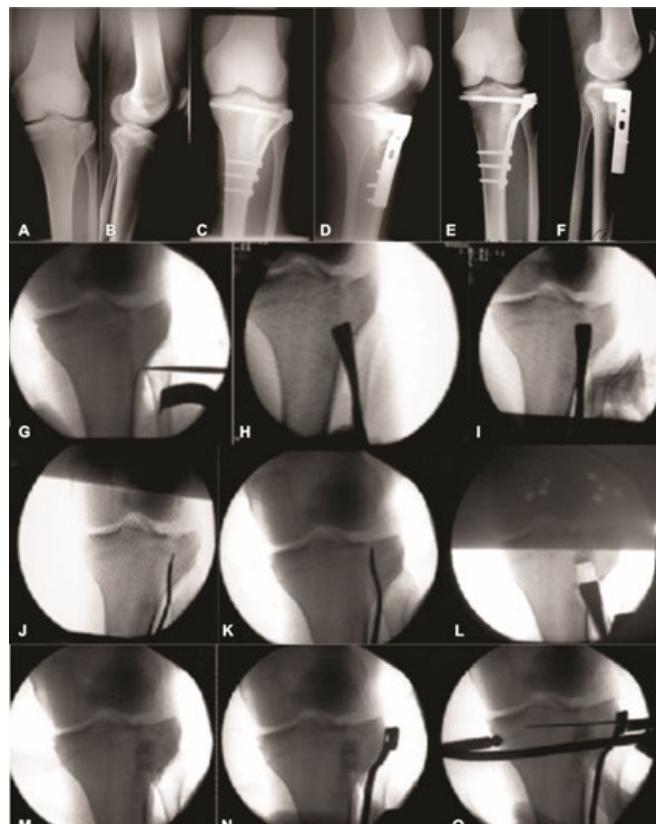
(A-O) Mixed fracture of the external tibial plateau (type B3/AO). Plate and bone substitute (A,B) preoperative X-rays; (C,D) postoperative; (E,F) X-ray control at 3 months (radiologic evidence of decreasing granular aspect of bone substitute); G - cortical window; (H-K) elevation of the articular surface; (L,M) Eurocer filled bone defect; (N,O) osteosynthesis with L-plate and screws
